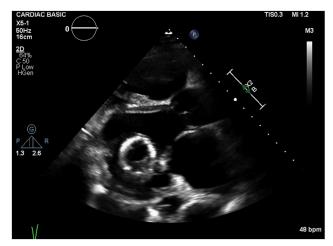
Two-dimensional TTE, parasternal long-axis view after valve deployment, demonstrates the embolized TAVI prosthesis within the LV.
